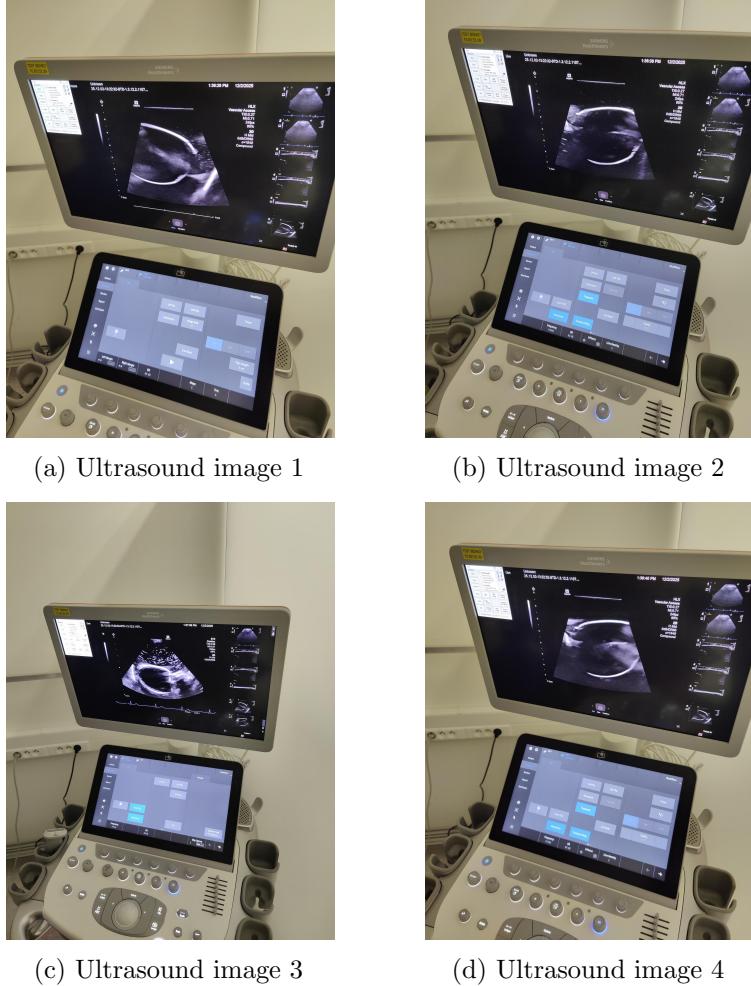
Ultrasound imaging results of the 3D-printed cardiac model
